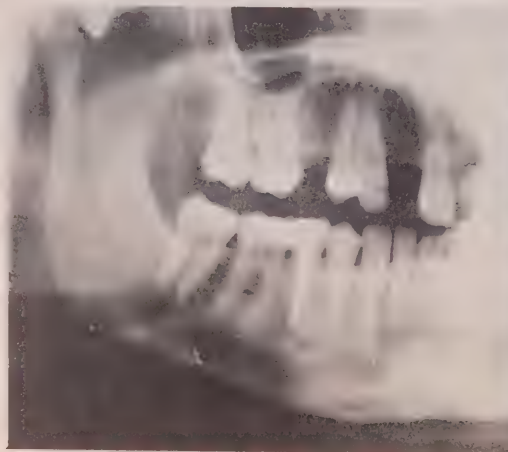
Panoramic radiograph four weeks after initial treatment. Good healing is evident.
